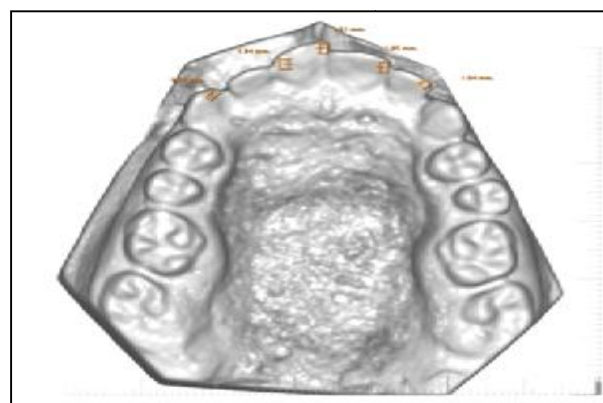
The method employed to measure little's irregularity index on CBCT image
